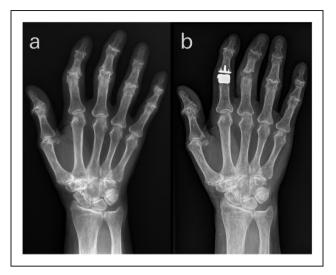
(a) Preoperative anteroposterior radiograph showing an axis deviation of greater than 15° at the index finger. The index finger PIP joint underwent a CapFlex-PIP surface-replacing arthroplasty and the middle finger received a silicone arthroplasty. (b) The radiograph taken at follow-up only reveals minimal residual axis deviation at the index finger fitted with the Cap-Flex implant and considerable deviation at the middle finger with the silicone implant.
